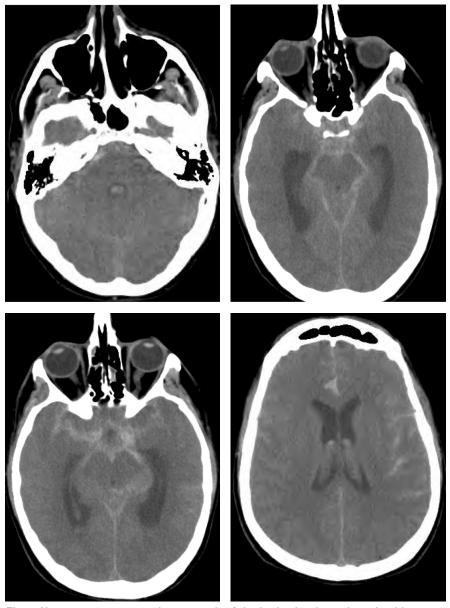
Non-contrast computed tomograph of the brain showing subarachnoid haemorrhage with hydrocephalus and blood extending into the lateral and fourth ventricles.
